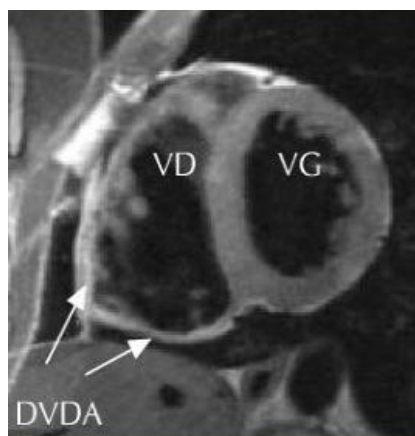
Image of Morphological MRI in a spin-echo sequence showing arrhythmogenic right ventricular dysplasia
